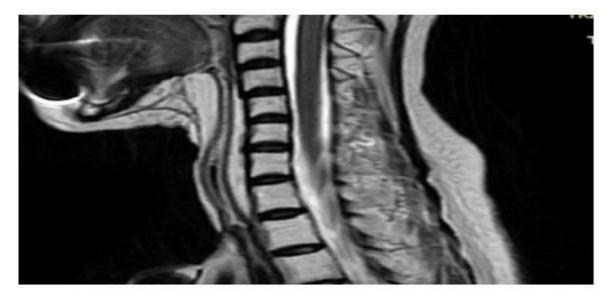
Videolaryngoscopy and MRI picture of a free radial flap 8 months after reconstruction of a circular pharyngeal defect.
